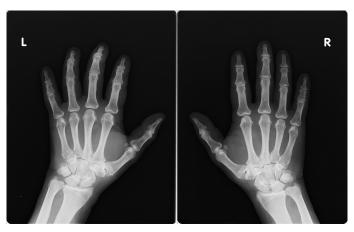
Plain radiography of the hand shows soft tissue swelling but no bony erosions or joint space narrowing.
